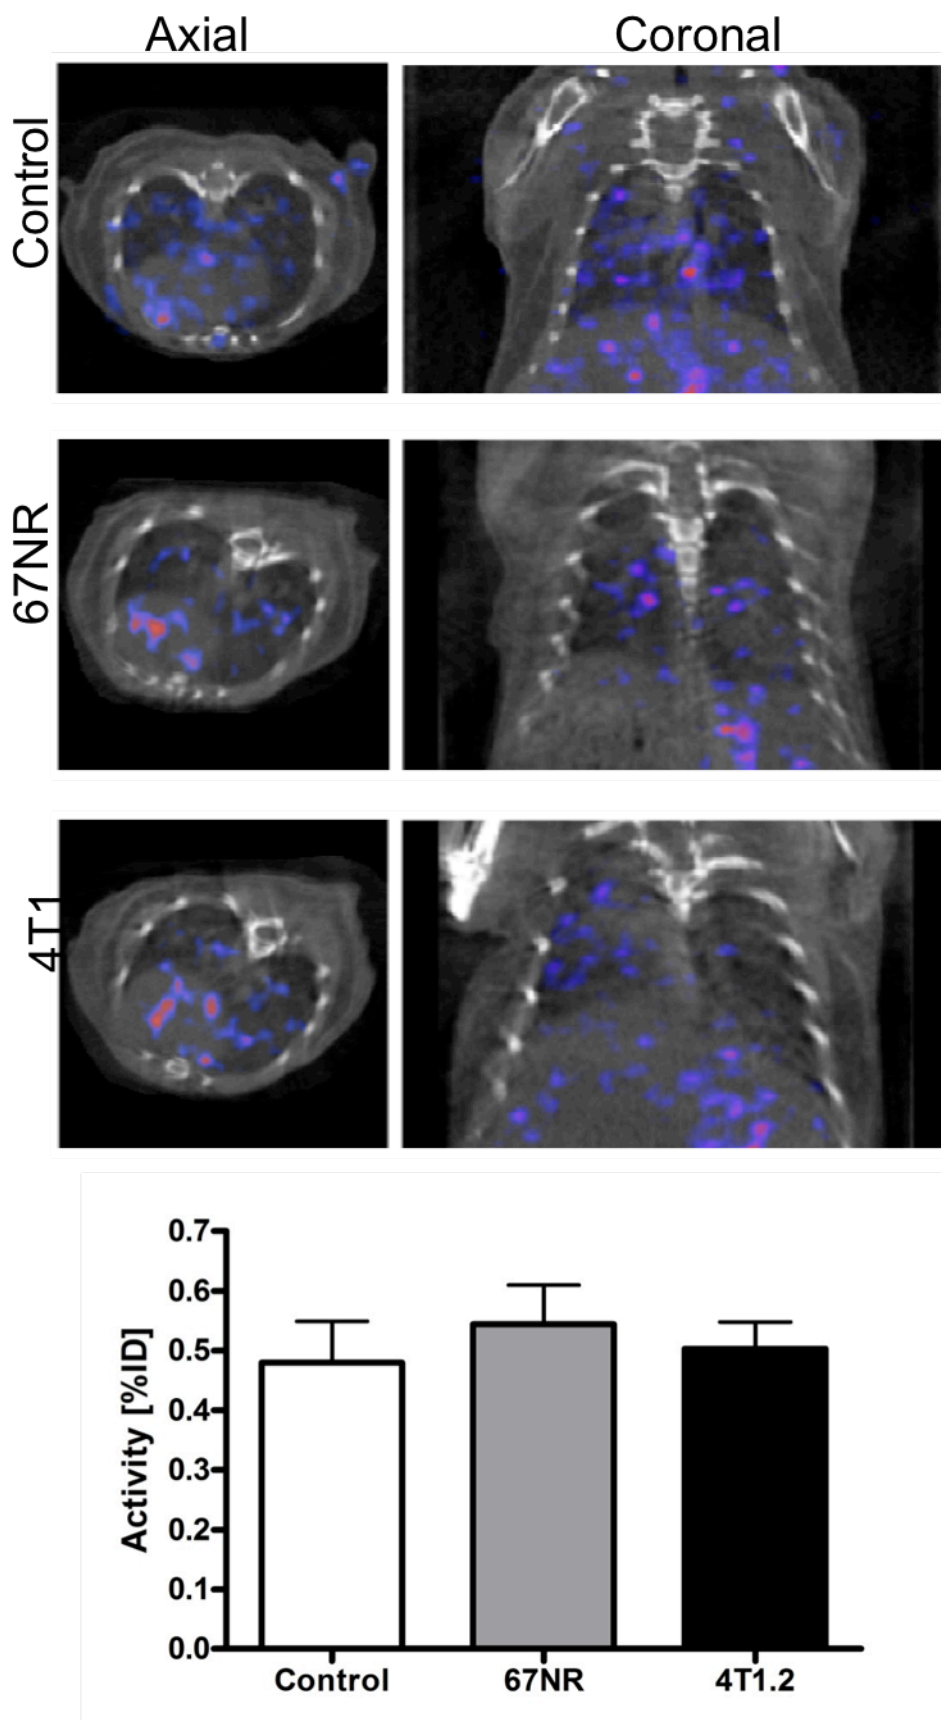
In vivo S100A9 SPECT – focus on the lungs.
